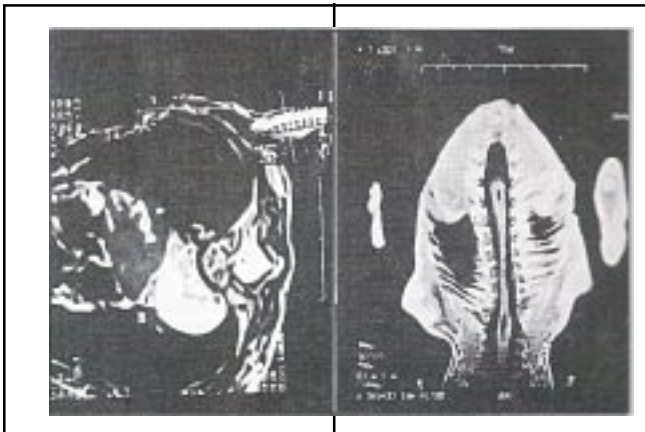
MRI showing hydrosyriago myelia at cervieu dorsal and lower dorsal region. Fig.2: MRI showing spinal neuro enteric cyst.
